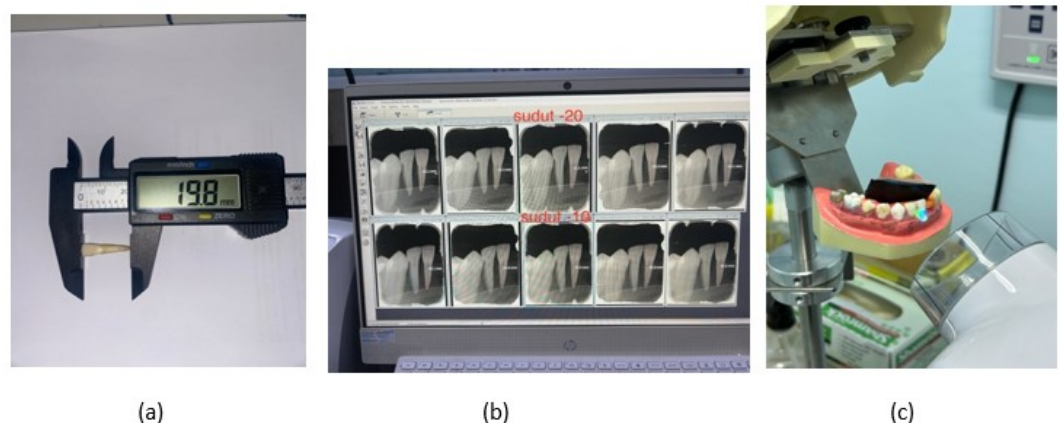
Research process on incisor 1, (a) Measurement of actual tooth length, (b) Radiograph with White and Pharoah angulation and measurement of radiograph, (c). X-ray tube alignment
